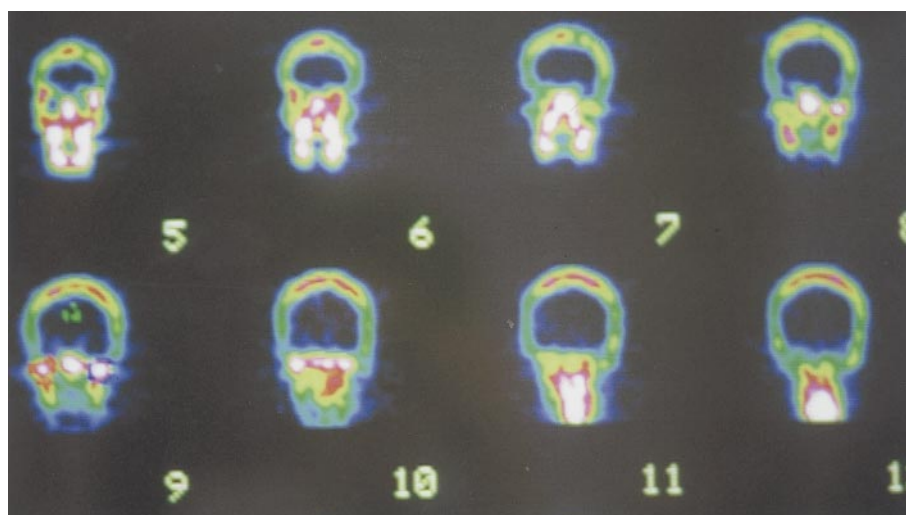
Coronal SPECT slices covering both TMJs. (Slices from 6 to 9 are shown.) The brighter tones represent higher radio-pharmaceutical uptake, which is consistent with an increase in bone metabolism.
